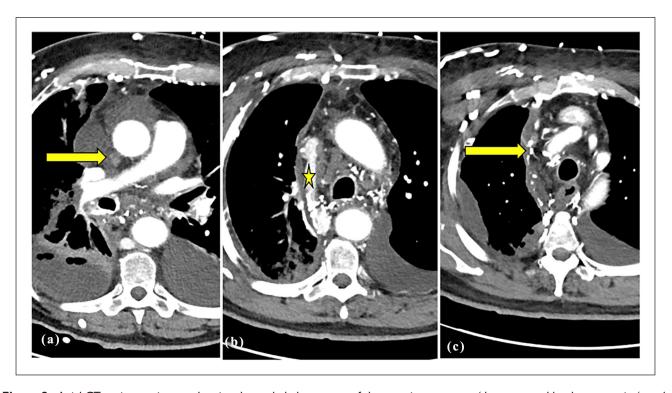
Axial CT angiogram images showing the occluded segments of the superior vena cava (demonstrated by the arrows in (a and c)). Most of the venous drainage occurs through the azygous vein (demonstrated by a star in (b)). CT: computed tomography.
